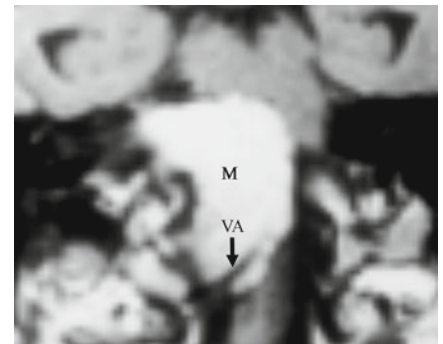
Lateral foramen magnum meningioma. A–C. Preoperative MRI with gadolinium in axial (A), sagittal (B), and coronal (C) views. D. Postoperative control after complete tumor resection. M: meningioma. V4l: left vertebral artery V4 segment. V4r: right vertebral artery V4 segment.
